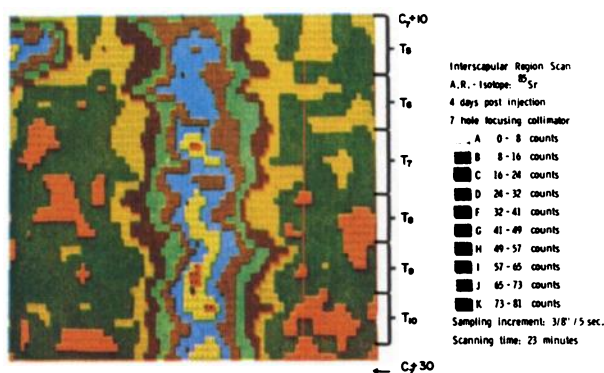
Focusing collimator search scan taken 4 days post-injection of ^{85}Sr over intrascapular region with patient prone reveals presence of area of increased uptake in left upper corner of scan corresponding to left 6th rib. Left-to-right counting-rate ratio of approximately 4 to 1 is seen. Area corresponds to 2×1 -cm lytic lesion site first detected by radiographs 35 days post-injection.
